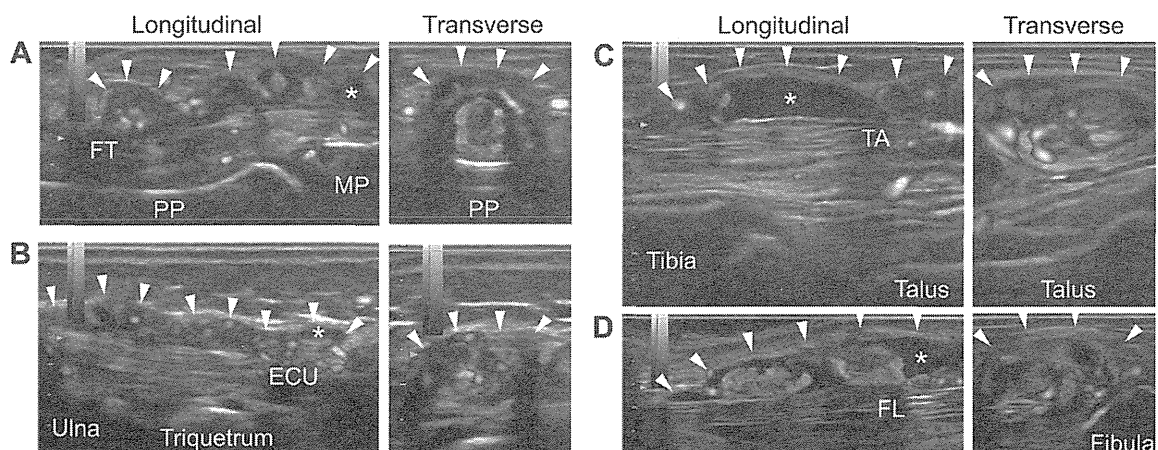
Ultrasound images of the right hand and the right ankle. A, The third flexor digitorum in the right hand. B, The extensor carpi ulnaris in the right wrist. C, The extensor tibialis anterior in the right ankle. D, The flexor digitorum in the right ankle.
